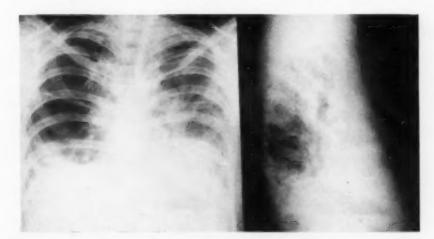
Chest roentgenogram of 22 year old man with marked decrease in total lung capacity, 24.7 per cent of normal predicted. The diagnosis has been established with reasonable certainty as lupus erythematosus. The residual air volume was 858 ml. and the vital capacity supine 773 ml.
